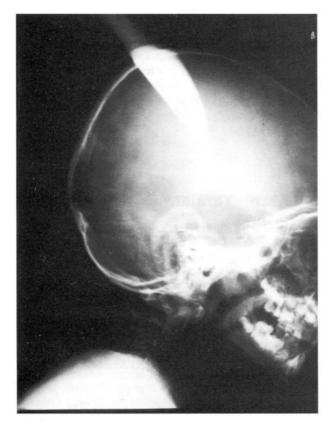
(Case 1): Lateral skull x-ray showing the knife blade in the right parietal area before removal.
